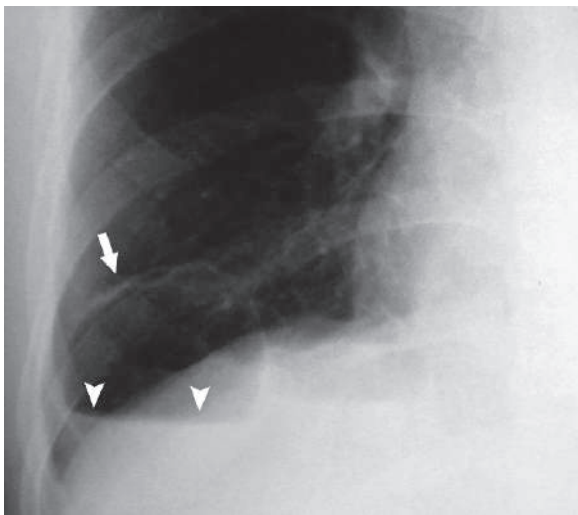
Posteroanterior plain chest radiograph shows ruptured hydatid cyst with floating water lily sign (arrowheads). Notice the cystic wall mimicking a cavity (arrow)
